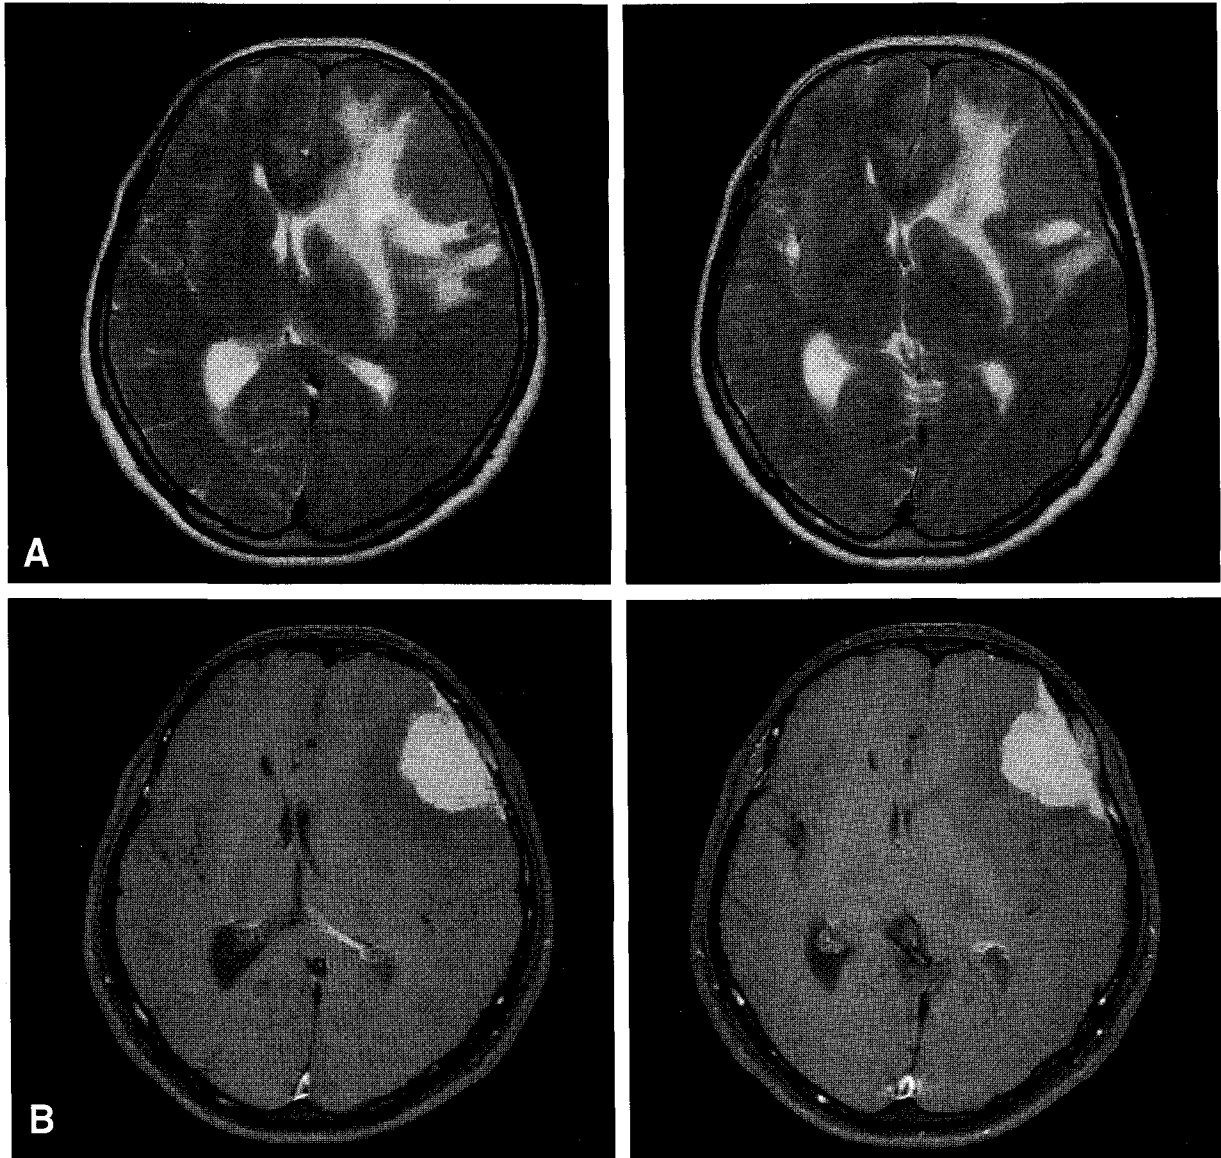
Axial T2-weighted (A) and gadolinium enhanced T1- weighted (B) images demonstrated a large round tumor mass in left inferior frontal lobe with its base on the anterior dura of the left frontal bone. (A) T2-weighted images demonstrated slightly hyperintense tumor relative to gray matter and compressed anterior horn of left lateral ventricle. (B) Following intravenous administration of gadolinium, an axial T1-weighted image demonstrated intense homogeneous contrast enhancement of this large dural based tumor.
